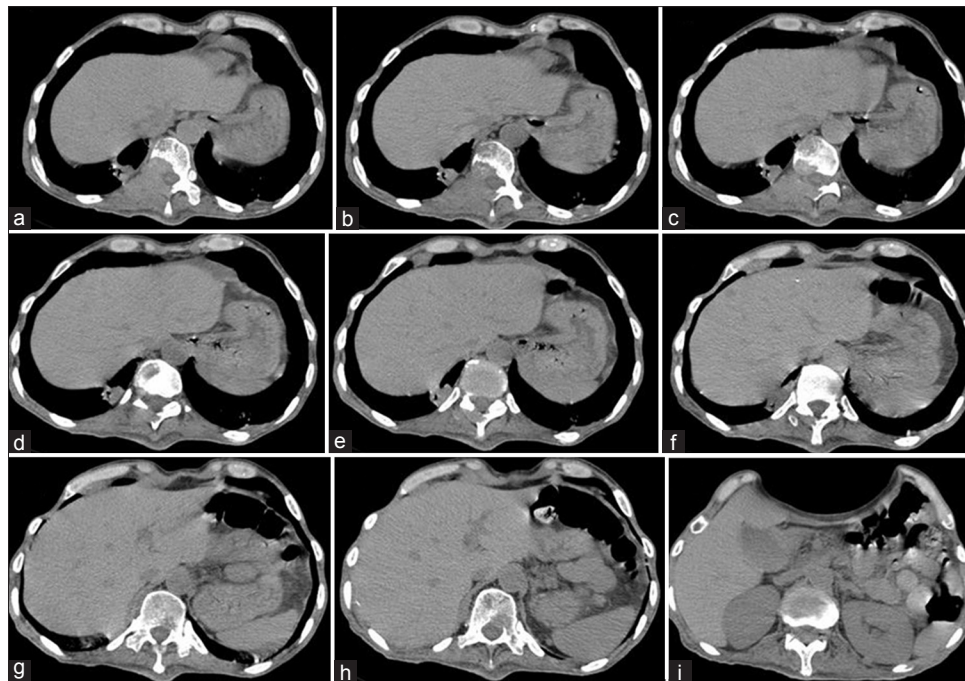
Transverse reconstruction of abdominal computed tomography scan (abdomen window): No pathological abnormality was diagnosed in the liver
